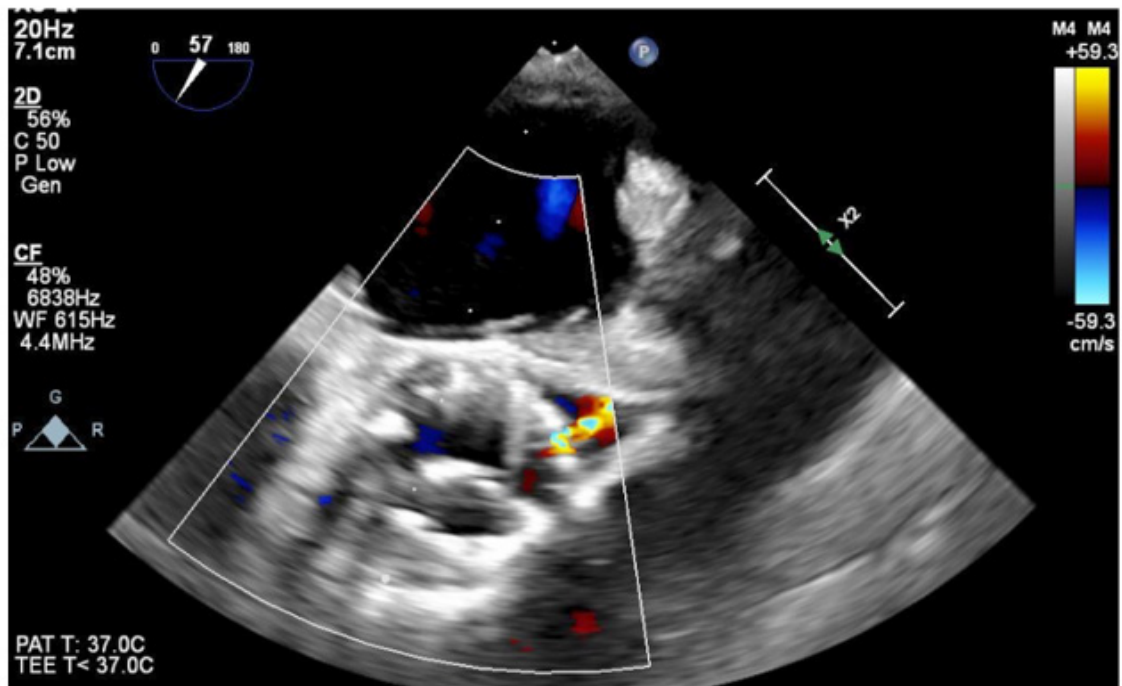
2D TEE view of mi esophageal right ventricular inflow-outflow with color flow Doppler demonstrating a high velocity systolic color flow jet directed to the ostium of the left main coronary artery (Philips X8-2t probe, Philips Healthcare, Andover, MA).
